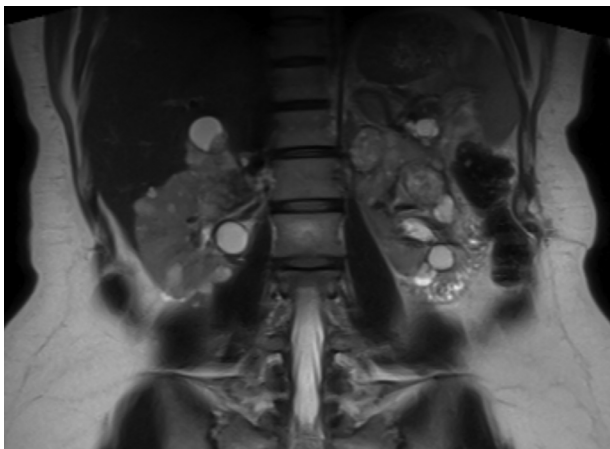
A 35-year-old female patient with Von Hippel-Lindau syndrome. Coronal T2w MRI imaging performed as part of screening demonstrates multiple bilateral renal cysts of varying complexity. Several solid renal lesions are shown bilaterally which have gradually developed from cysts whilst under observation. The patient has had multiple resections of Fuhrman grades I and II clear cell RCCs.
